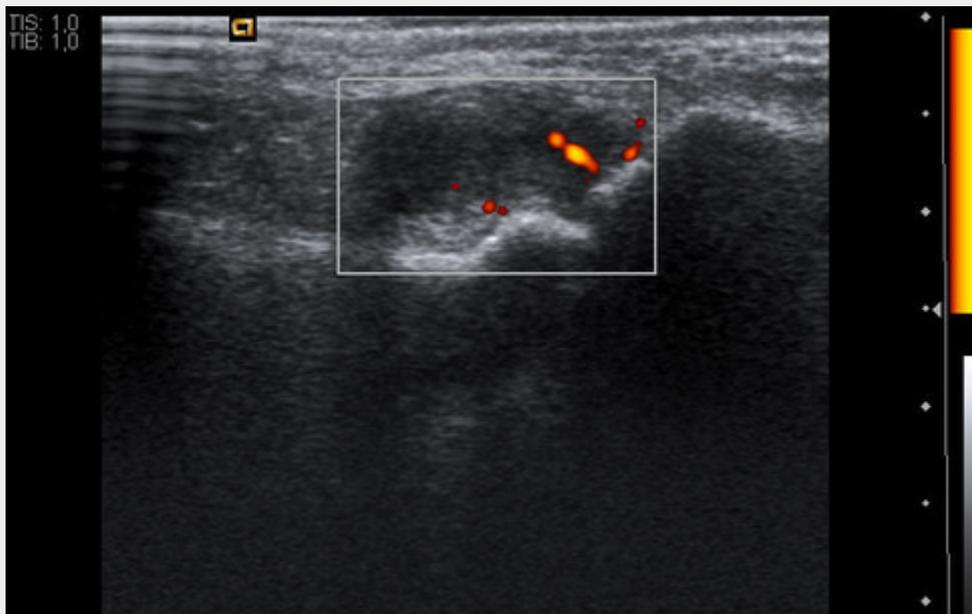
Power-Doppler US - Metatarsophalangeal joint showing synovial thickening and Doppler signal indicating active synovitis (Psoriatic arthritis).
